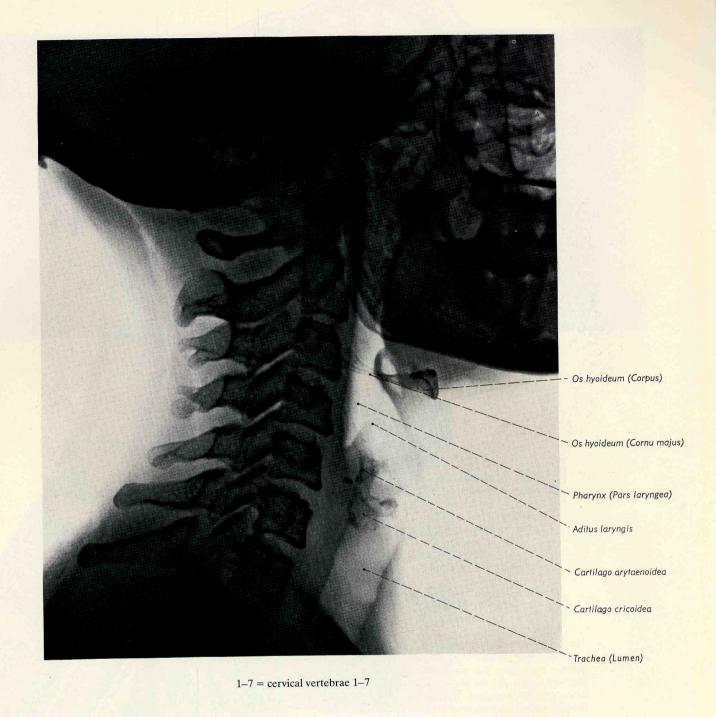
Lateral roentgenogram of the soft structures in the laryngeal and tracheal regions (from R. Kraus, Heidelberg).
